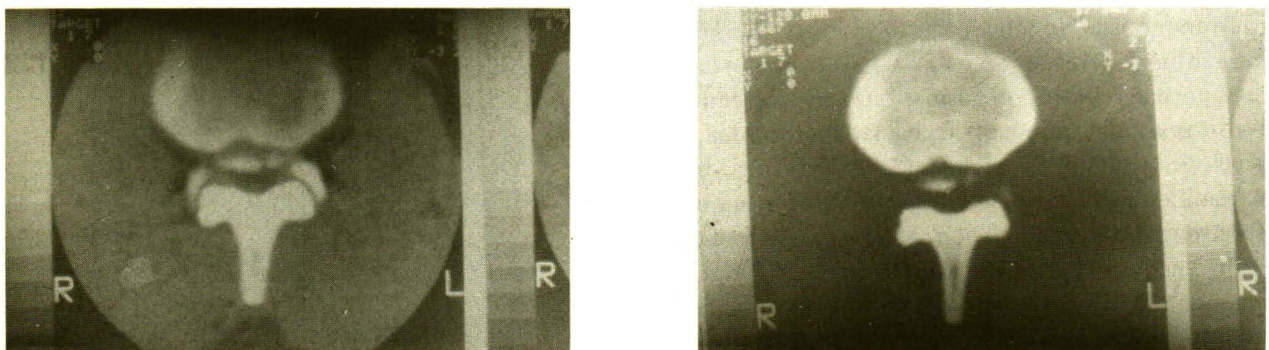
CT scan revealed rupture of the disc and fracture of the cartilagenous end plate.
